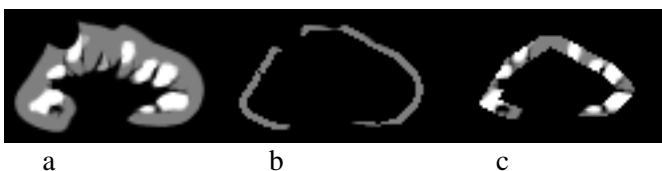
A virtual MRI slice (a) and the contents of outer (b) and inner (c) ROI.
